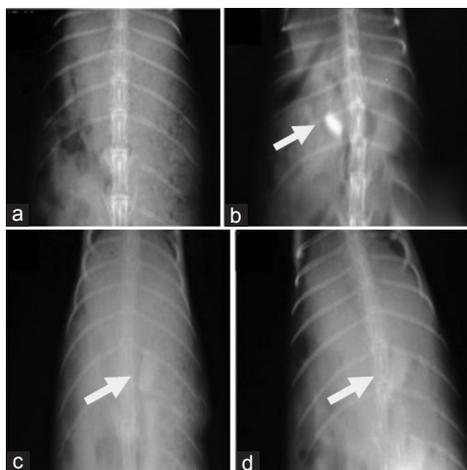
X-ray photographs showing floating ability of valsartan floating tablet formulation at different time intervals, (a) 0 h, (b) 2 h, (c) 6 h, and (d) 12 h (arrow mark indicating the location of the tablet)
